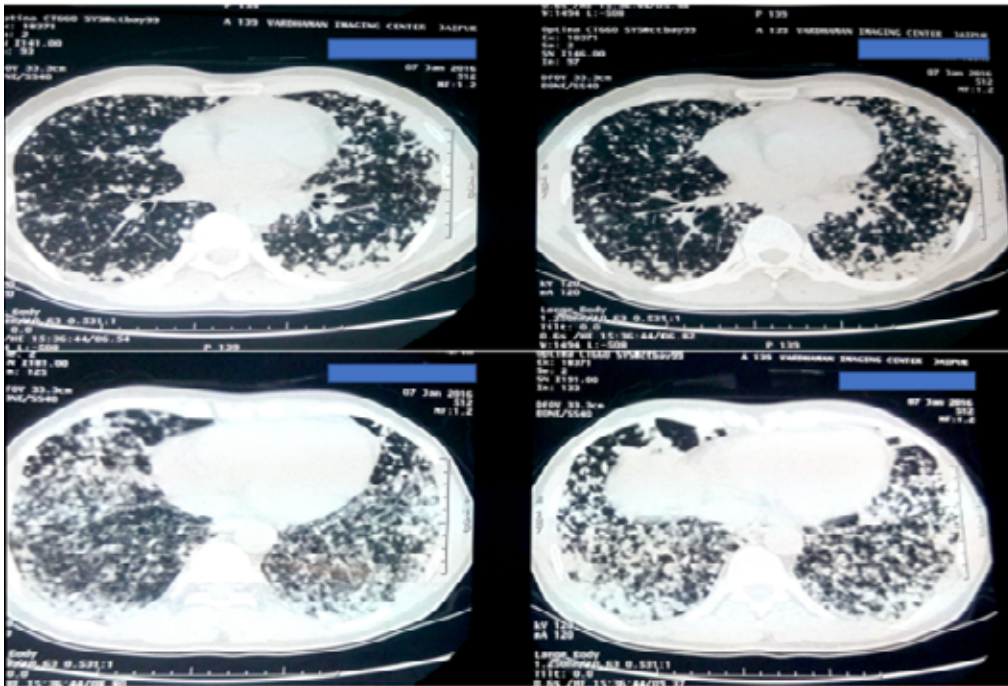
HRCT of the thorax axial section lung window showing random distribution of nodules with subpleural involvement and conglomeration of nodules.
